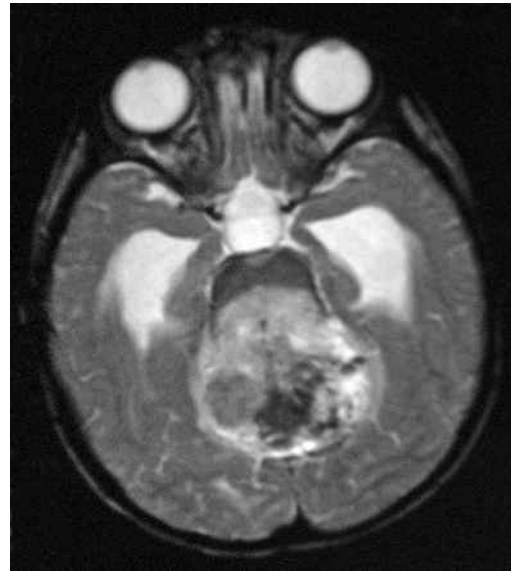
Axial T2-W MR image of the brain shows marked hypointensity areas within the mass, which are slightly hyperintense on the T1-W image at the corresponding areas. These features are consistent with intracellular methaemoglobin. There was acute dilatation of the third and lateral ventricles with CSF seepage.
